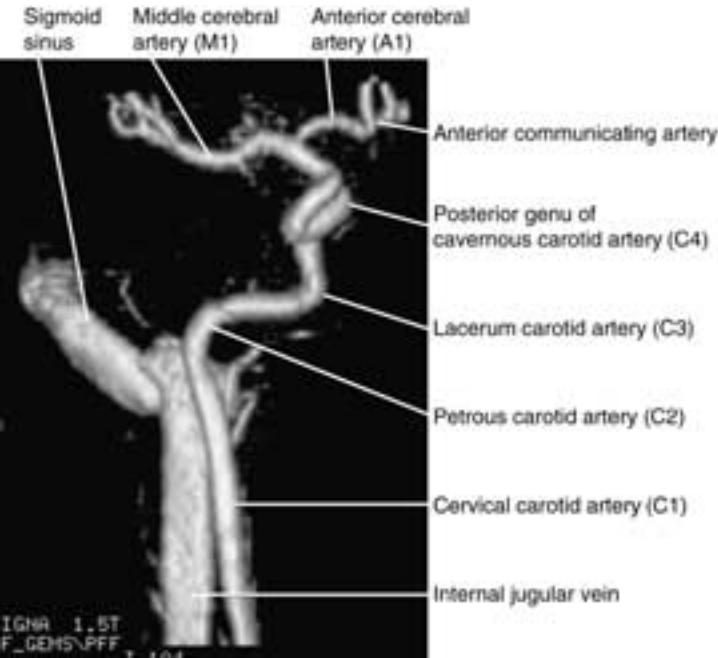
Two-dimensional time-of-flight MR image. Anterior surface reconstruction MRA. This is a surface reconstruction of a 2D MR angiogram acquisition obtained without any saturation pulses or contrast enhancement. It allows visualization of both the arterial and venous systems. The carotid and jugular vessels in the neck are parallel to each other. As they enter the temporal bone, they separate, with the carotid artery turning medially and the jugular vein laterally. The carotid is anterior to the jugular system.
